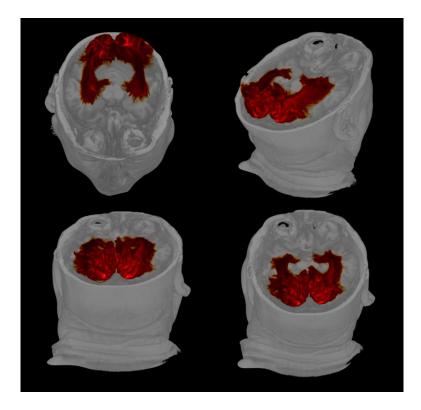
3-dimensional rendering of optic radiation track density superimposed over the subject's T1-weighted MPRAGE scan in MRtrix3.
